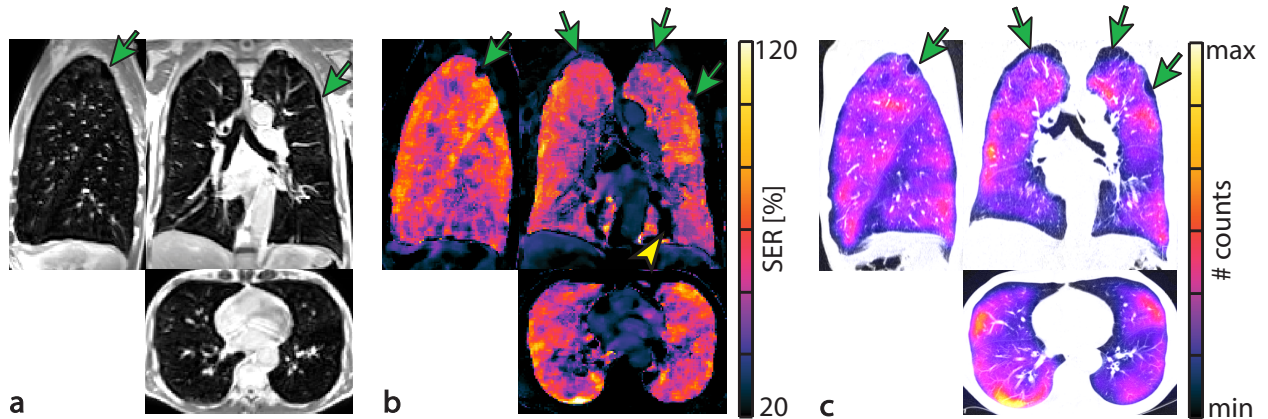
Comparison of post-contrast ufSSFP (a), ufSSFP-SER (b), and ^{99m}Tc -MAA SPECT/CT fusion images (c) in a 70-year-old male patient with COPD GOLD IV. In this patient, a more uniform distribution of emphysema compared to the patients presented in Figure 3 and Supporting Figure S5 was observed. A homogenous but still patchy decrease in SER is noted (whole lung SER = $57\% \pm 28\%$, mean \pm SD). Again there is a good visual agreement between ufSSFP-SER imaging and SPECT/CT, e.g. in the regions of bullous emphysema in the apices (green arrows). In (b), a pulsation artefact from the heart is indicated by the yellow arrowhead.
